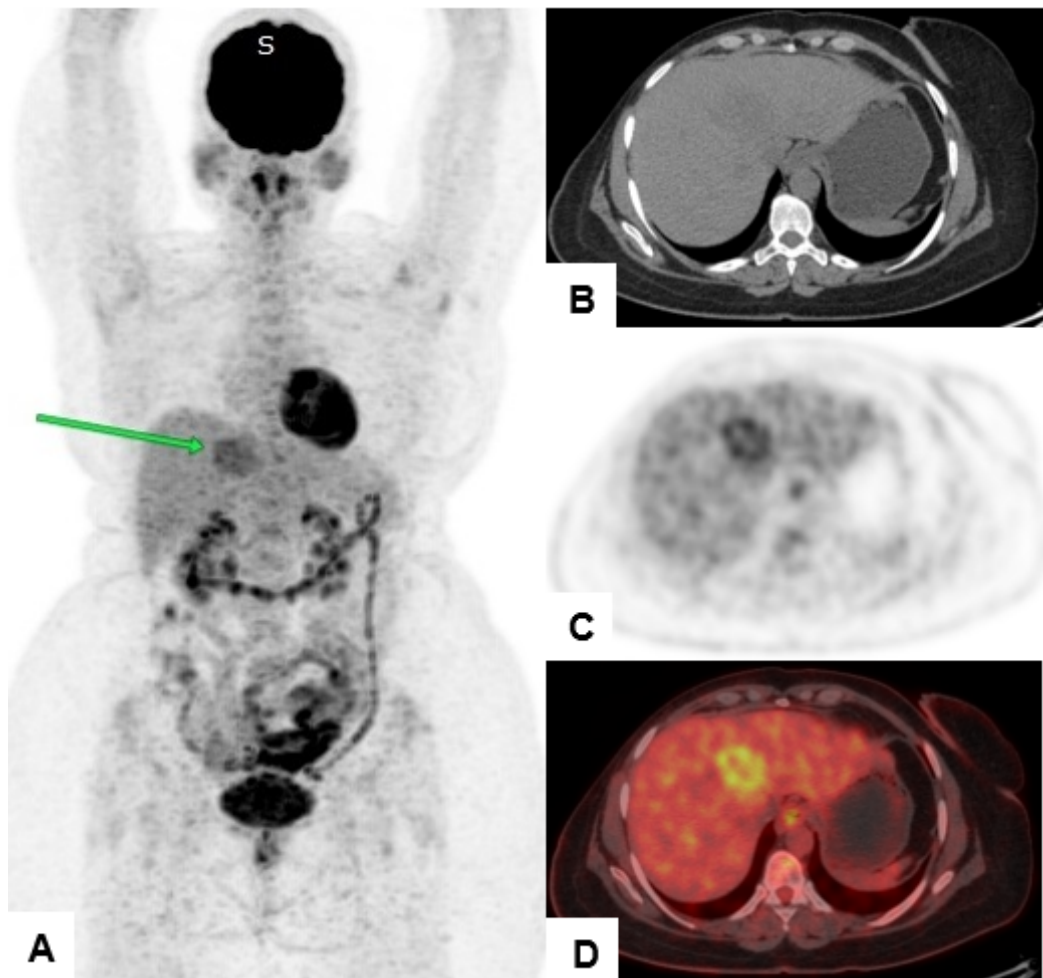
Delayed 18F-FDG PET/CT images highlighting a hypermetabolic lesion in segment IV of the liver. (A) Maximum-intensity-projection FDG-PET image; (B) axial CT image; (C) corresponding axial PET image; and (D) fused PET/CT image acquired 120 minutes after injection. The solitary lesion demonstrates an SUVmax of 7.6, with reduced hepatic background activity.
